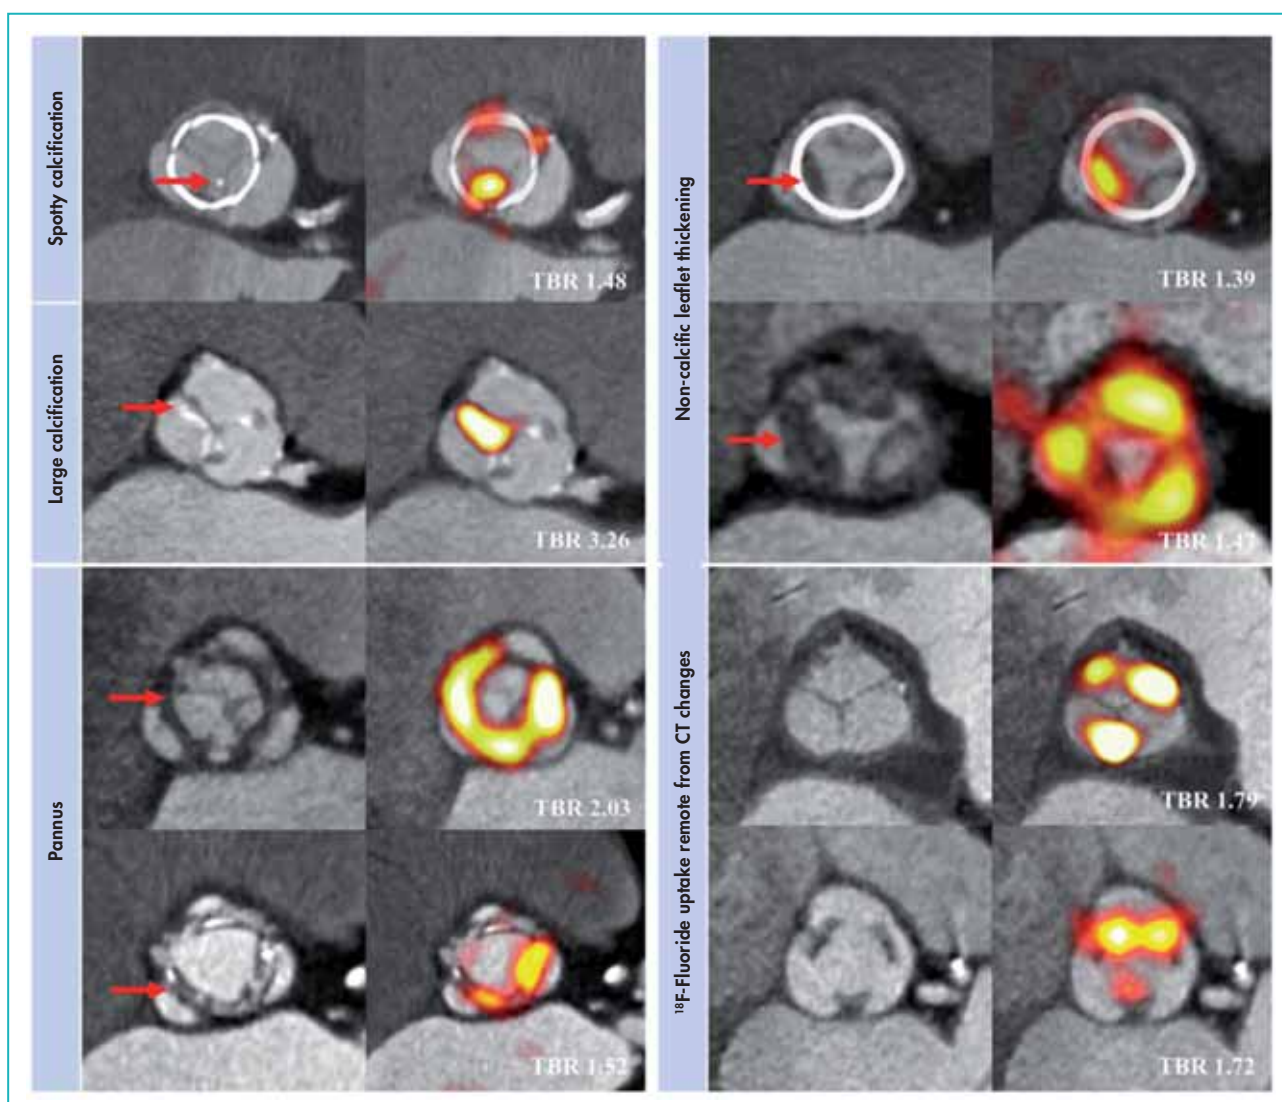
In vivo* ^{18}F -fluoride positron emission tomography and computed tomography imaging of patients with bioprosthetic aortic valves.
